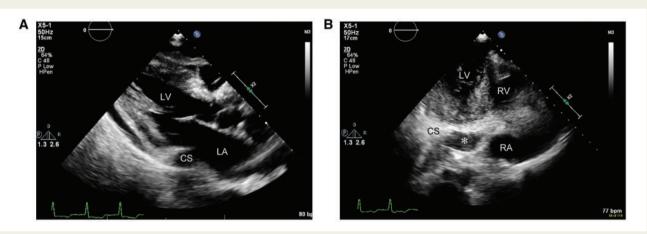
Two-dimensional echocardiography of (A) parasternal long view and (B) apical four chamber view. (A) Parasternal long axis view demonstrates dilated coronary sinus and small <1 cm pericardial effusion. (B) Targeted apical four chamber view demonstrating dilated coronary sinus occupied by thrombus (*). CS, coronary sinus; LA, left atrium; LV, left ventricle; RA, right atrium.
